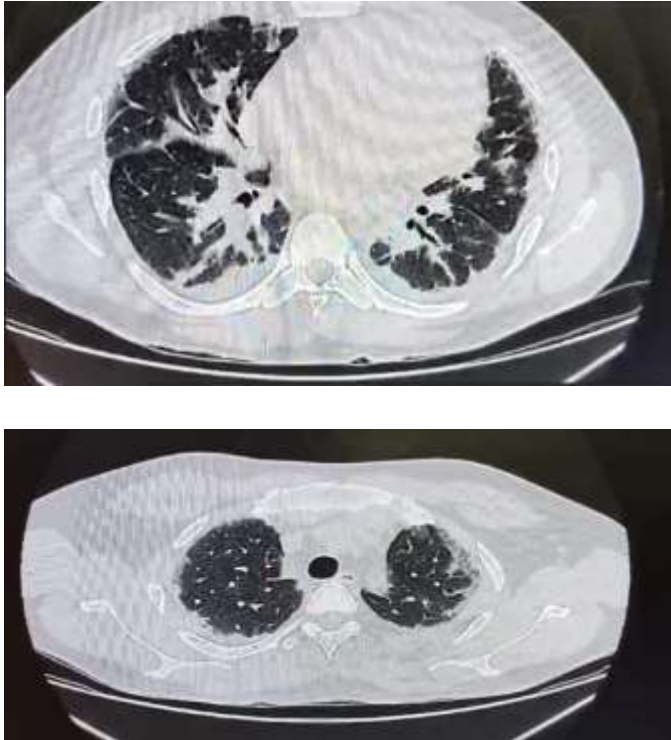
CT thorax suggestive of bilateral pleural effusion with basal atelectasis, ground glass opacities with subsegmental atelectasis in bilateral upper lobes
